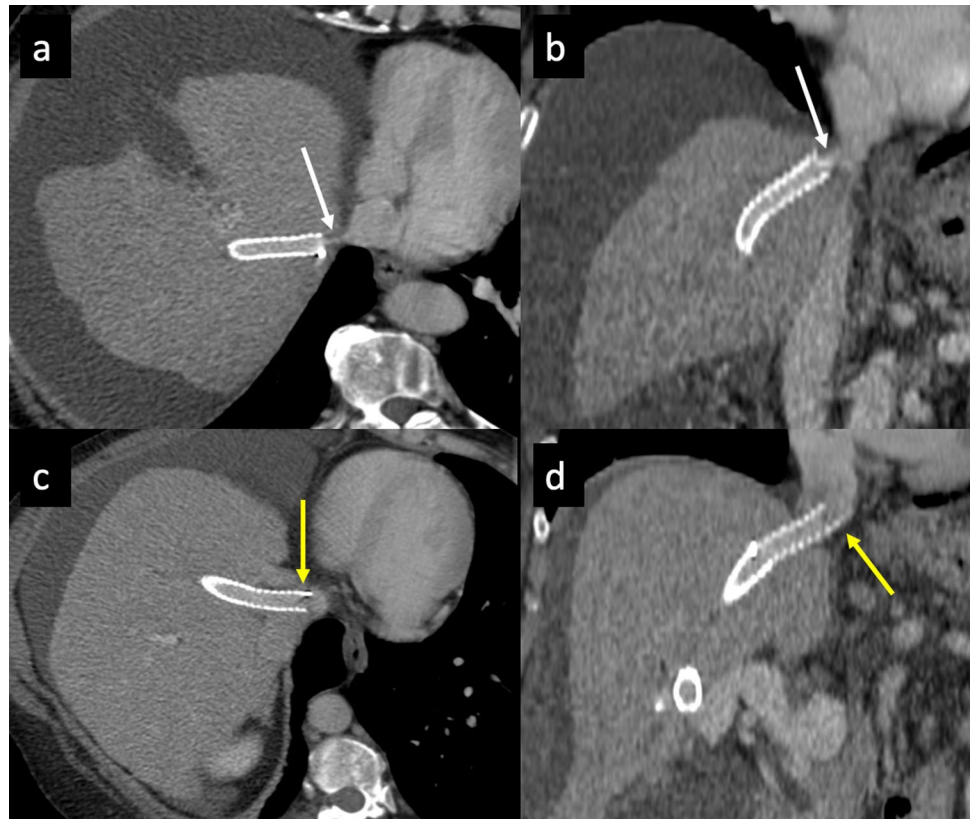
Stent malposition. Axial (a) and coronal (b) contrast-enhanced CT images show a stent with the distal edge too short in the right hepatic vein, leaving a gap that led to stenosis (white arrows). Contrast-enhanced CT multiplanar reconstruction (MPR) images (c, d) show a stent with a proximal edge that is too long extending into the IVC (yellow arrows)
